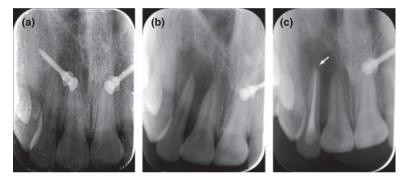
Radiograph after placement of miniscrews (a), maxillary right lateral incisor tooth with periapical radiolucency (b) and after root canal filling (c). Arrow showing the root damage.
